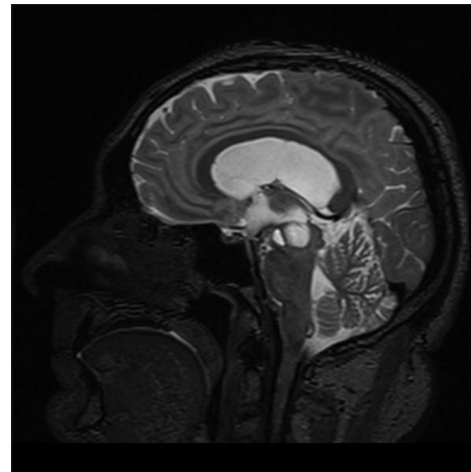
Magnetic resonance imaging sagittal T2-weighted sequence demonstrating cystic perivascular spaces in midbrain tegmentum with distention of the third ventricle and bowing of the corpus callosum
